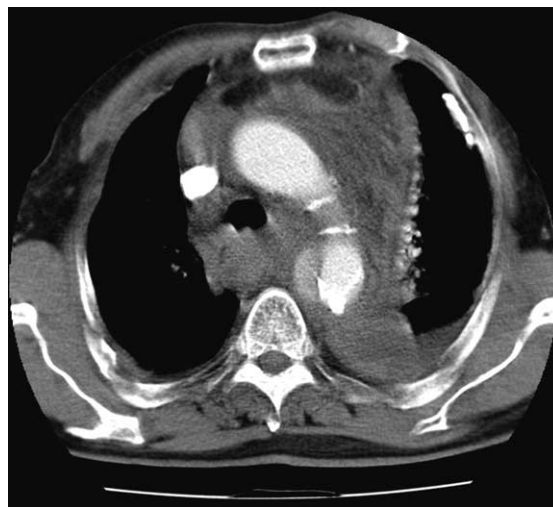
Axial CT-scan from patient with ruptured acute aortic type B dissection.
